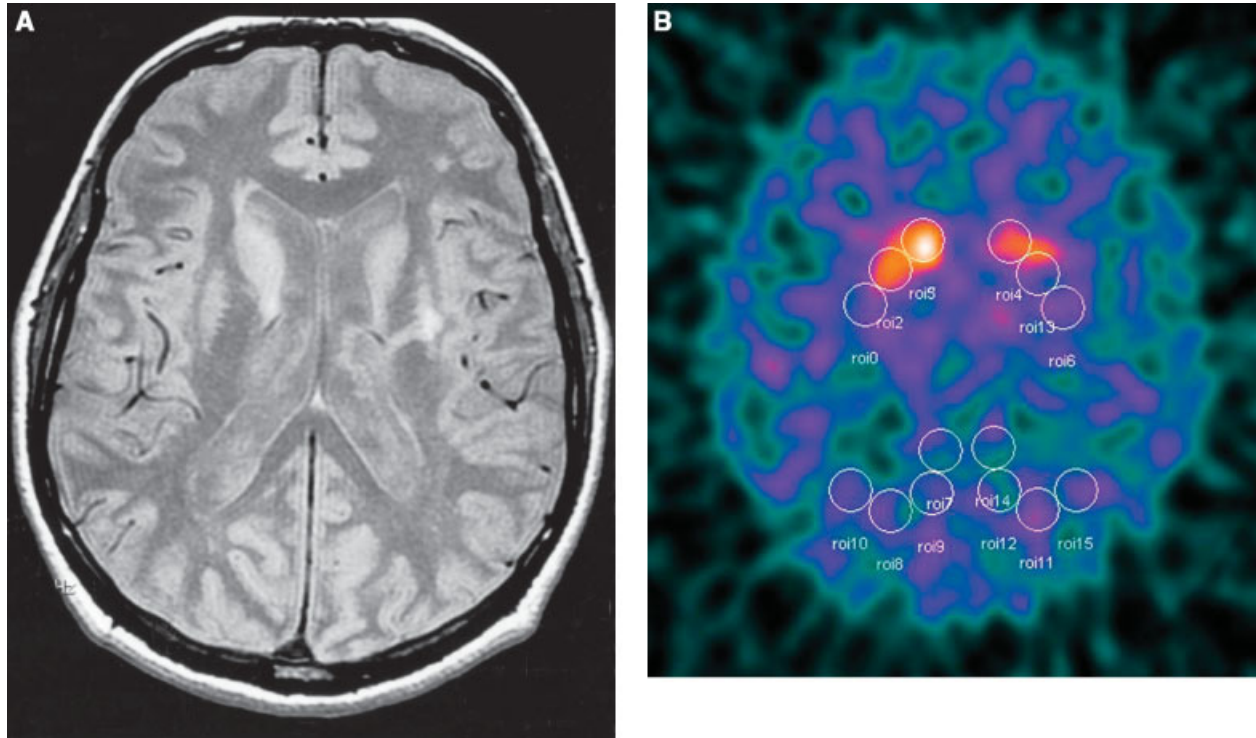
(a) Proton density weighted axial MRI scan of a 56-year-old VP patient showing a lacunar infarction involving the left corona radiata and extending inferiorly into the putamen. Two years earlier, the patient had experienced a sudden onset of bradykinesia and postural tremor of the right hand, no right arm swing when walking, with normal power and no rigidity, together with transient dysphasia, dysarthria and right-sided facial weakness. Subsequently, there was slow and gradual improvement. The L-dopa response was positive. (b) His SPECT scan revealed FP-CIT uptake reduction that was much more severe in the left than in the right striatum. The asymmetry index was 5.81.
